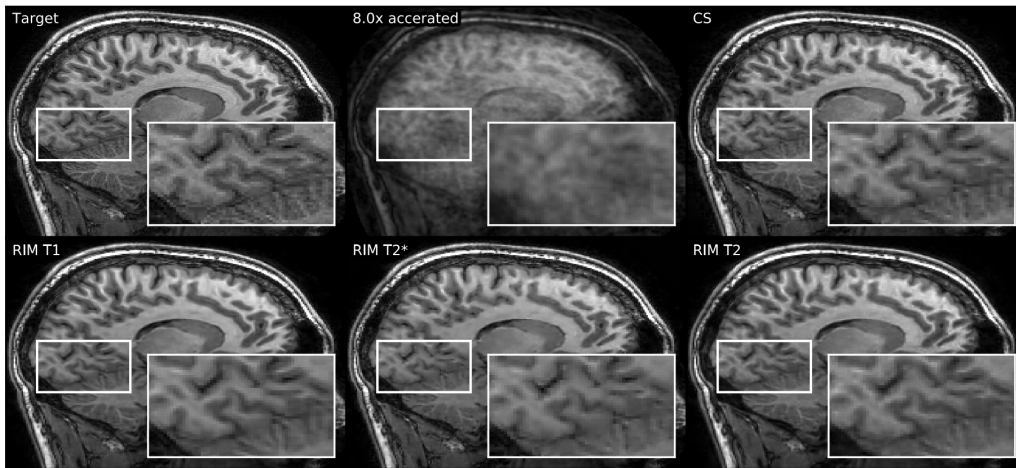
(Image from [4]) Shows the 8 time accelerated images of a T1-weighted scan. Trained on T1, T2\* and T2 weighted models. On the eye, there are very little differences.
